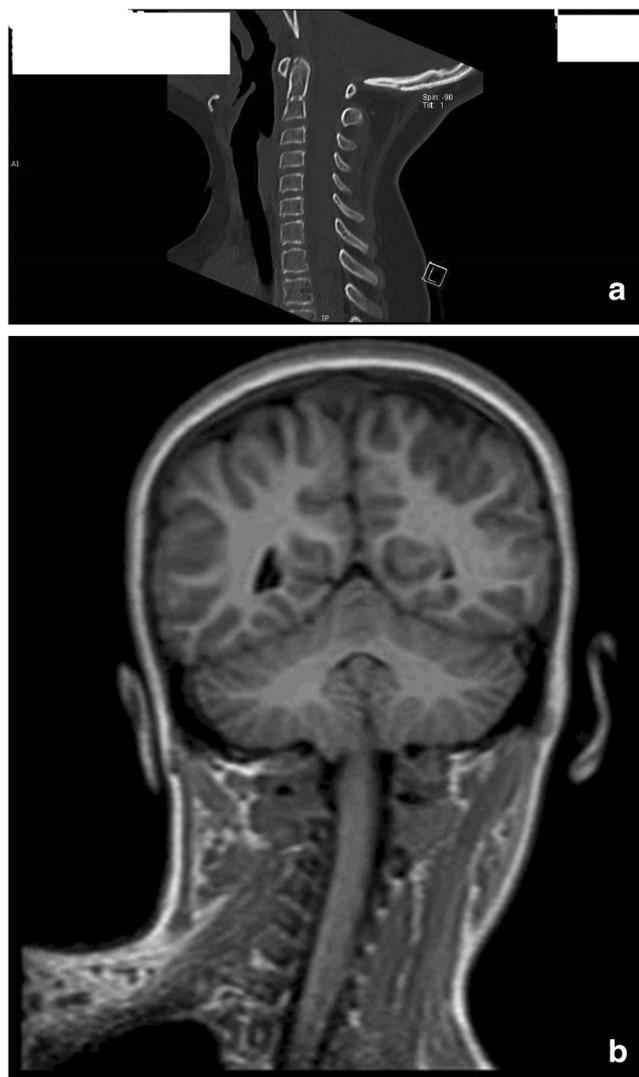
a CT scan of the child showing rotary articular subluxation of the C1-C2 cervical tract. b Cervical and brain MRI showing rotary articular subluxation of the C1-C2 cervical tract, and signs of inflammation of the adjacent neck tissues
